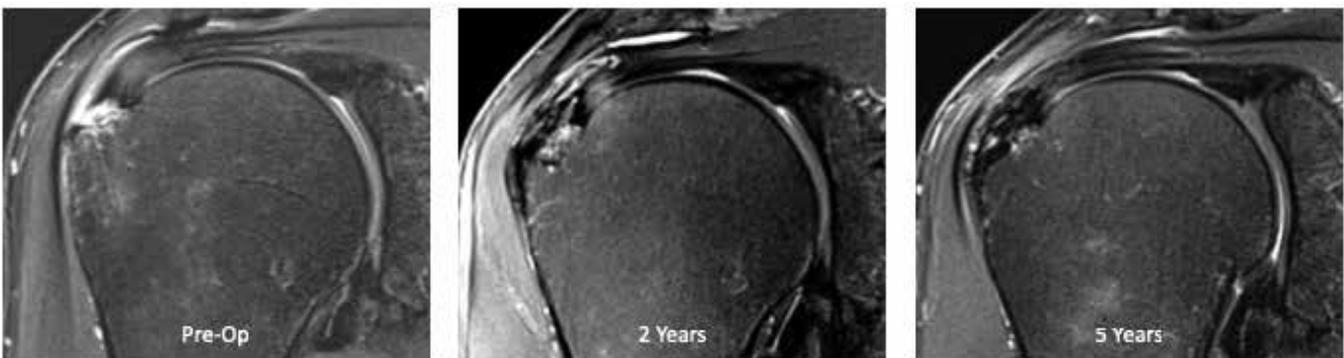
MRI images of high-grade, intra-substance partial-thickness tear followed over 5 years.
